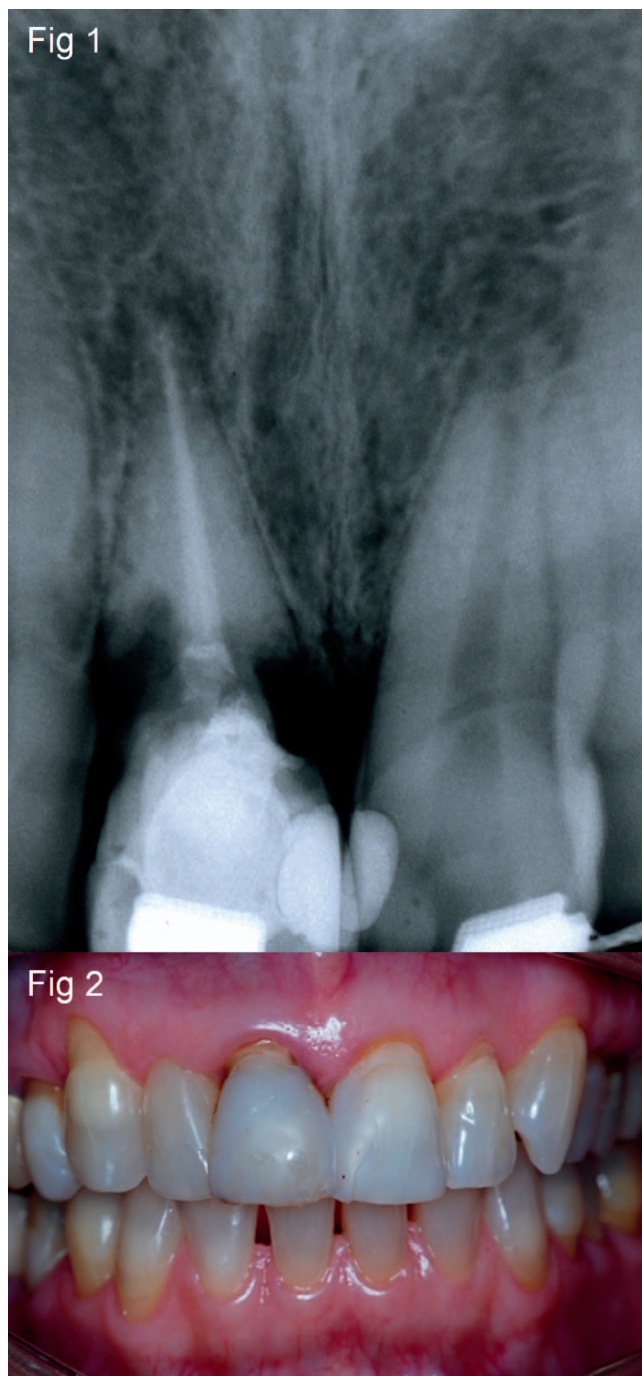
Initial periapical radiograph.
